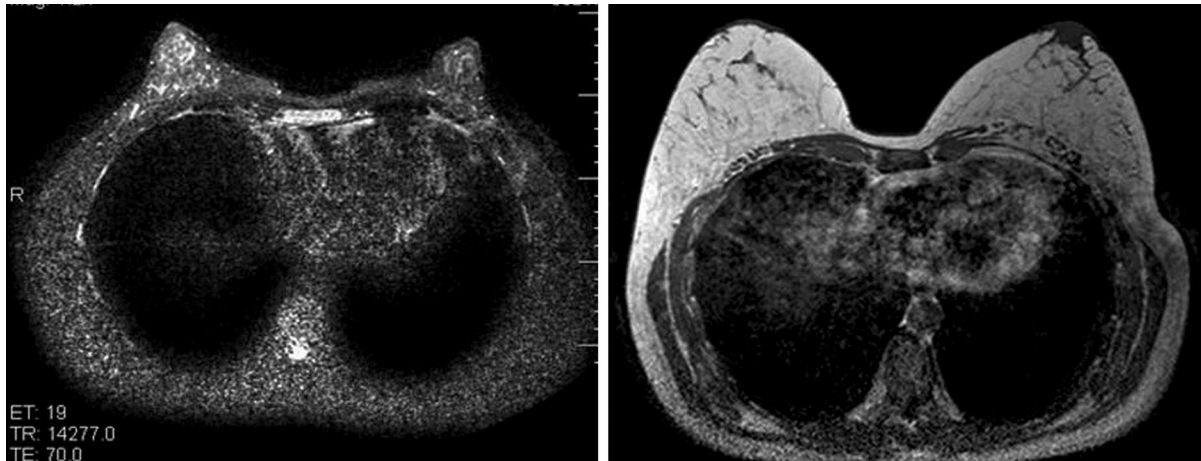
Case 3. (Left) Preexpansion magnetic resonance imaging scan of the patient. (Right) Scan obtained 6 months after the second fat grafting procedure. An increase of 300 cc was measured.
